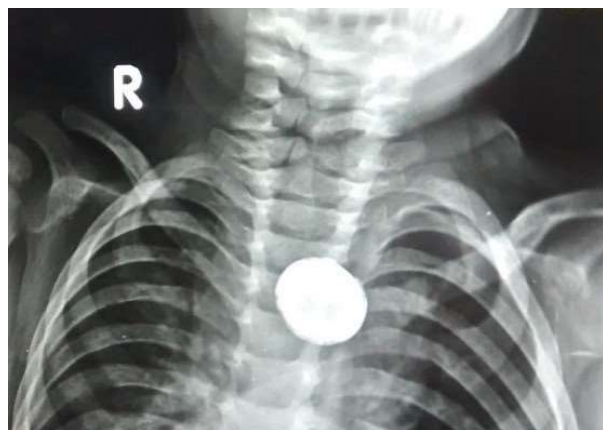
Chest X-ray AP view confirming foreign body lodged in upper esophagus
